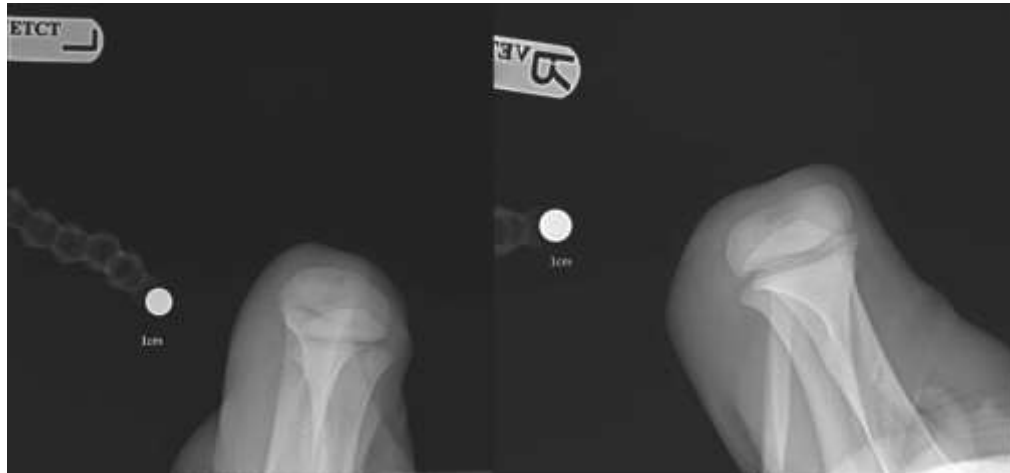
Skyline radiographic views of the both stifle joint. The trochlear grooves of both femurs were normal and patella bone was not observed between the grooves.
